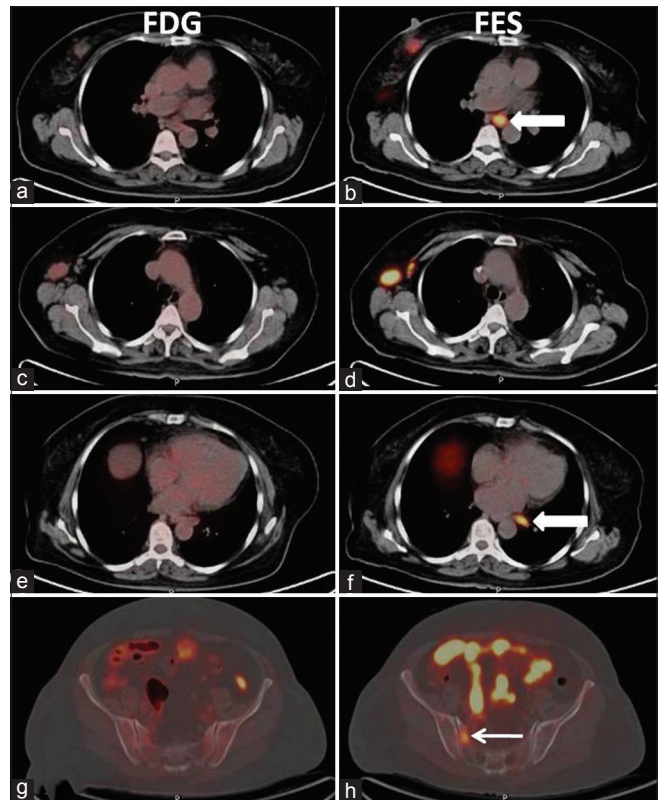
Axial fused ¹⁸F-fluorodeoxyglucose (a, c, e, and g) and fused ¹⁸F-fluoroestradiol (b, d, f, and h) positron emission tomography-computed tomography images. Images show strongly ¹⁸F-fluoroestradiol-positive disease sites. Two mediastinal lymph nodes (white block arrow, image b and f) and sacral lesion (white arrow, image h) were not appreciable on corresponding ¹⁸F-fluorodeoxyglucose images
